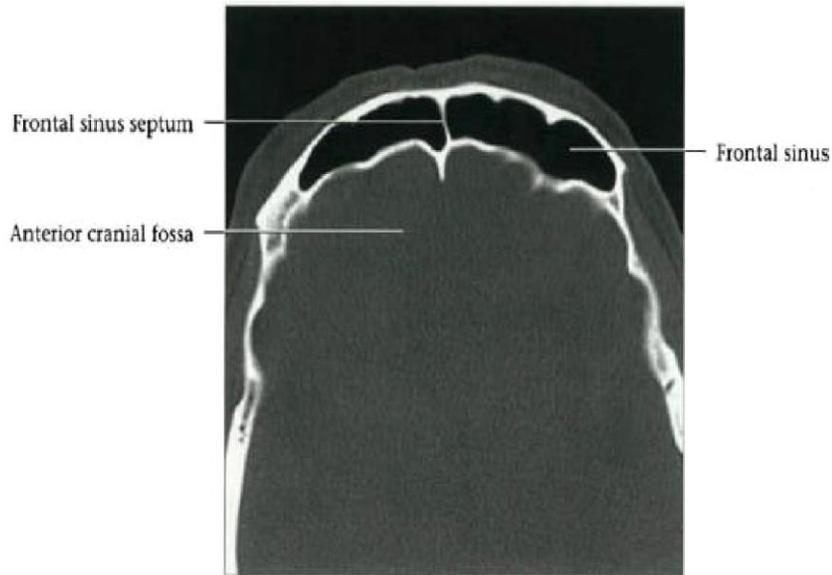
axial CT bone window shows the frontal sinuses with their midline septum, and thin posterior wall, separating the sinuses from the anterior cranial fossa. Frontal sinus disease can extend posteriorly in to the cranial vault. (Harnsberger et al., 2006).
